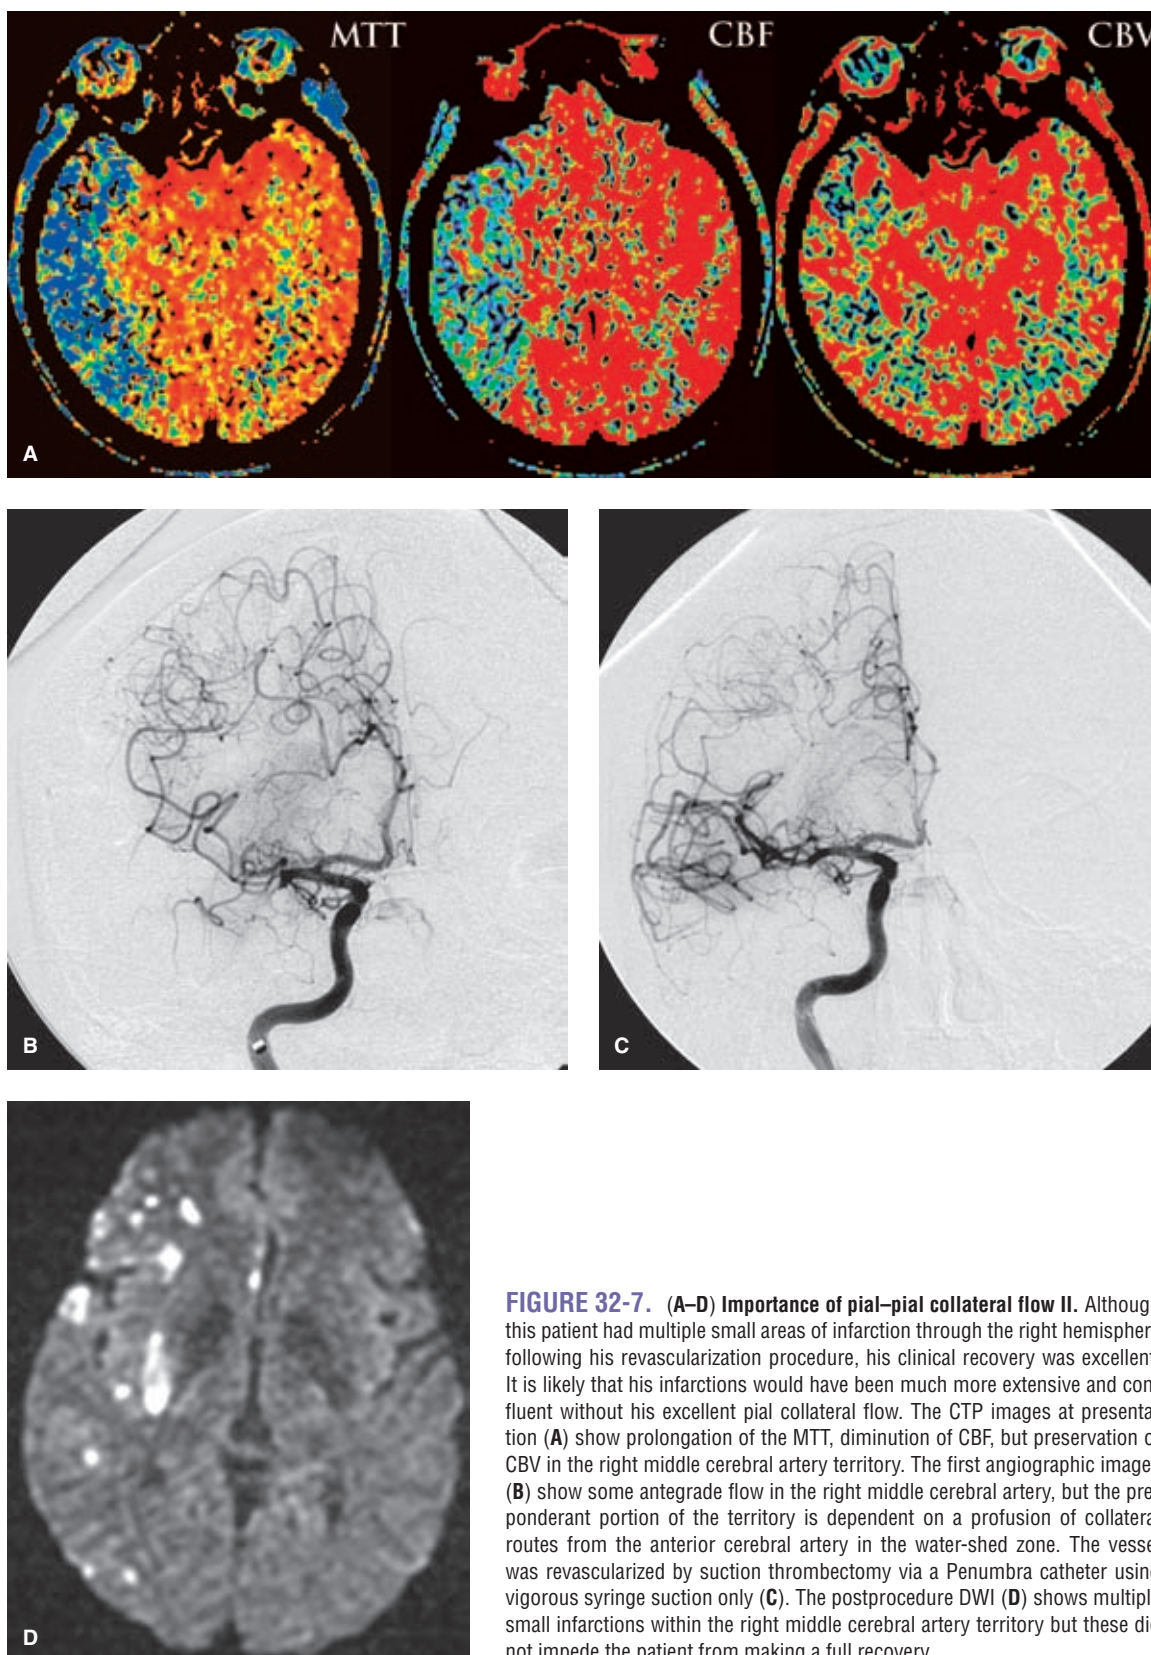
(A–D) Importance of pial–pial collateral flow II. Although this patient had multiple small areas of infarction through the right hemisphere following his revascularization procedure, his clinical recovery was excellent. It is likely that his infarctions would have been much more extensive and confluent without his excellent pial collateral flow. The CTP images at presentation (A) show prolongation of the MTT, diminution of CBF, but preservation of CBV in the right middle cerebral artery territory. The first angiographic images (B) show some antegrade flow in the right middle cerebral artery, but the preponderant portion of the territory is dependent on a profusion of collateral routes from the anterior cerebral artery in the water-shed zone. The vessel was revascularized by suction thrombectomy via a Penumbra catheter using vigorous syringe suction only (C). The postprocedure DWI (D) shows multiple small infarctions within the right middle cerebral artery territory but these did not impede the patient from making a full recovery.
